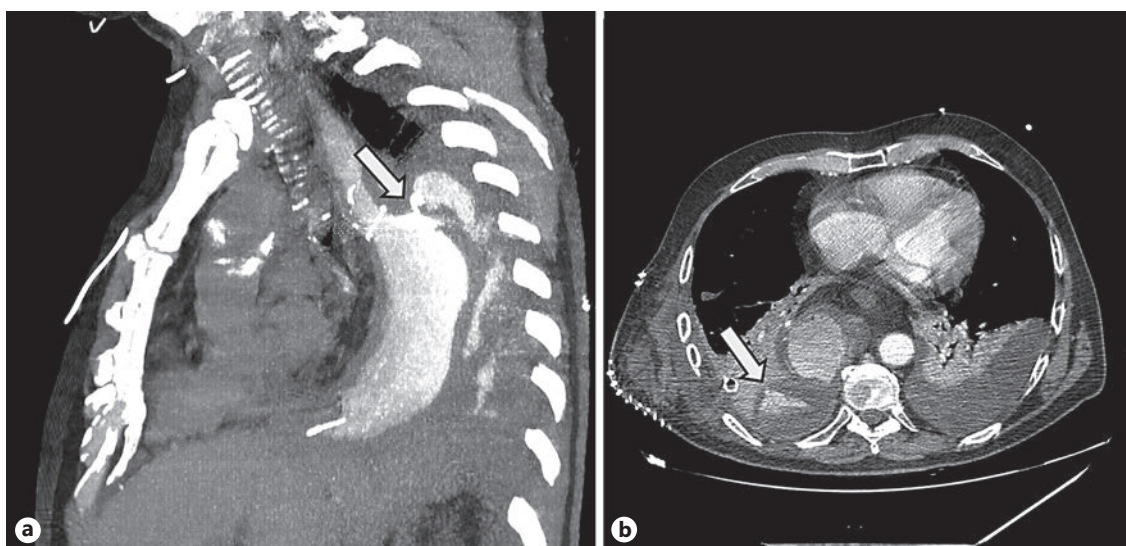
Computed tomography. a Dehiscence of the gastric staple line of the esophagogastric anastomosis (arrow). b Gastropleural fistula with oral contrast in the pleural cavity (arrow).
